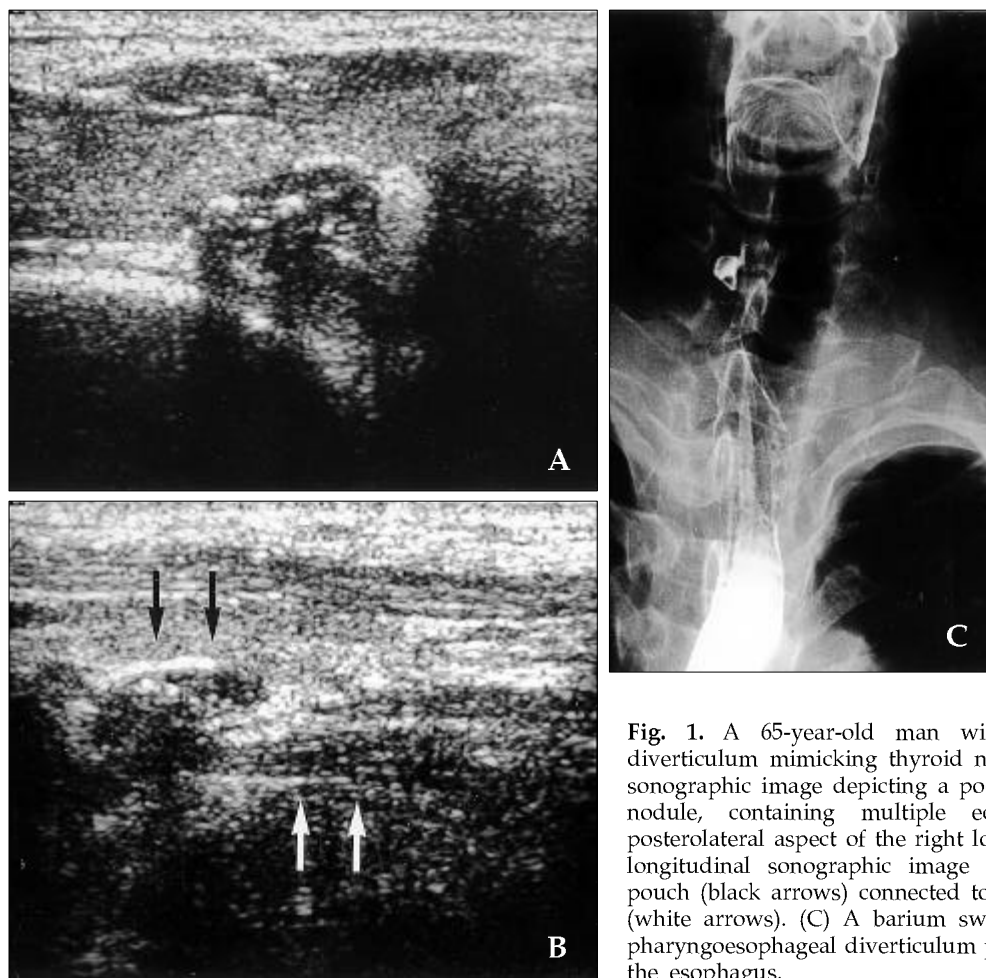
A 65-year-old man with pharyngoesophageal diverticulum mimicking thyroid nodule. (A) A transverse sonographic image depicting a poorly defined hypoechoic nodule, containing multiple echogenic foci in the posterolateral aspect of the right lobe of the thyroid. (B) A longitudinal sonographic image depicting a protruding pouch (black arrows) connected to the cervical esophagus (white arrows). (C) A barium swallow study confirms a pharyngoesophageal diverticulum projecting to the right of the esophagus.
